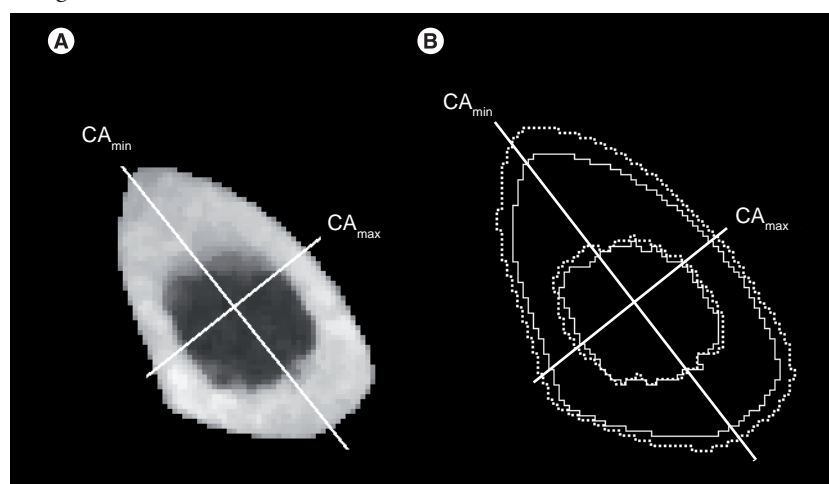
Peripheral quantitative computed tomography images of the tibial midshaft from the Action Schools! BC study. (A) Representative baseline pQCT image of an intervention boy's left tibia with the CA_{max} and CA_{min} superimposed. (B) Superimposition of the baseline (solid) and follow-up (dashed) bone surfaces demonstrates the primary anatomic sites where bone was formed in response to the intervention. The alignment of these images was based upon minimization of pixel greyscale differences. The apparent trend for greater periosteal apposition on the anterior and posterior surfaces lead to a significantly greater gain in bone bending strength (I_{max}) in intervention boys compared with controls. CA_{max} : Maximum centroidal axis; CA_{min} : Minimum centroidal axis; I_{max} : Maximum second moment of area; pQCT: Peripheral quantitative computed tomography. Adapted from [40] with permission from Springer.
